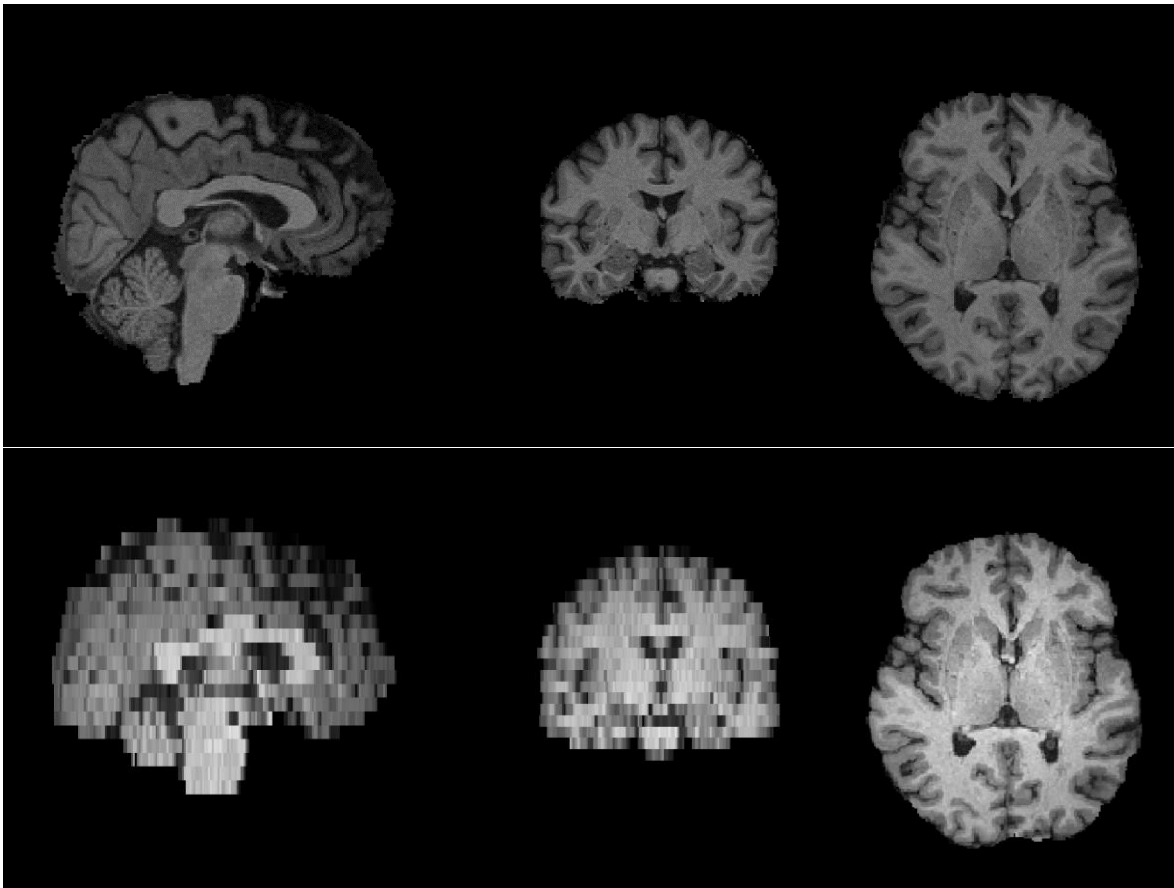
Noticeable spatial resolution loss suffered from a T1-weighted image (upper panel) after being registered to the corresponding FLAIR scan (lower panel).
